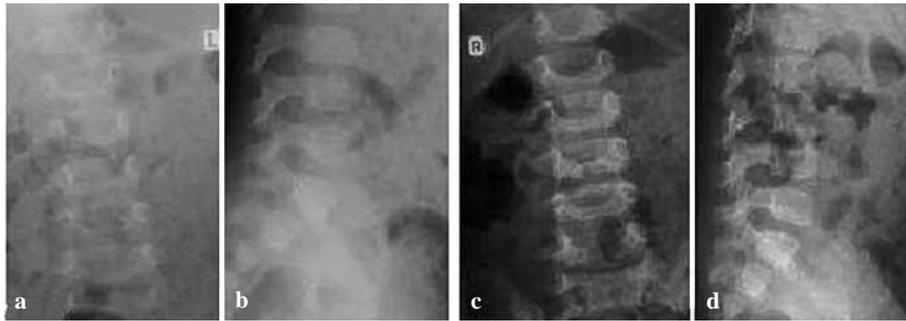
a-b. Initial radiographs : narrowing of the intervertebral space L3-L4 and irregular borders of the adjacent vertebral end-plates ; c-d. Radiographs after one year show a slight dextroconvex scoliosis and reduced lumbar lordosis.
